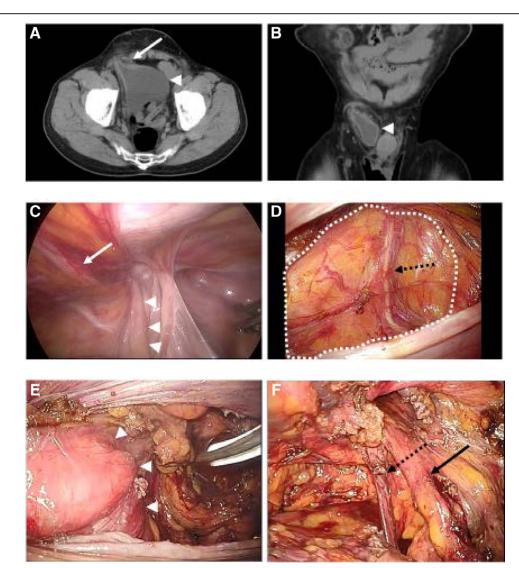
Preoperative and intraoperative findings for case #39. (a), (b) The hernia CT scan shows that the bladder slides into the inguinal canal from the outside of the inferior epigastric artery and vein. (c) Intraoperative findings. The bladder was sliding from the outside of the inferior epigastric artery and vein. (d) When the preperitoneal cavity was dissected from the outside, the bladder appeared in a partition-like shape, making it difficult to dissect off the Retzius space. The spermatic code was found on the bladder. (e) After the dissection, the bladder was returned from the inguinal canal into the preperitoneal space. (f) The post-dissection findings were similar to those of a typical indirect inguinal hernia. White arrow: inferior epigastric artery and vein. White dotted area: bladder. Black arrow: testicular artery and vein. Black dotted arrow: spermatic code. CT = computed tomography.
